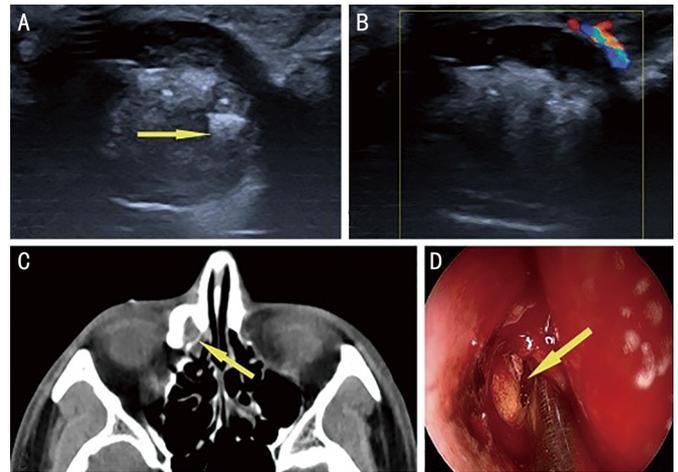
Imaging features of mucopeptide concretions in CDU and CT-DCG A: An oval-shaped mass with a clear, not-smooth edge and uneven internal echoes was detected on conventional ultrasound, with echo attenuation indicated by the yellow arrow; B: CDU showed no blood flow signal within the mass; C: Soft tissue mass in the lacrimal sac was observed without obvious bone destruction (yellow arrow); D: A large mucopeptide concretion was found during surgery (yellow arrow). CDU: Color Doppler ultrasound; CT-DCG: Computed tomography dacrycystography.
